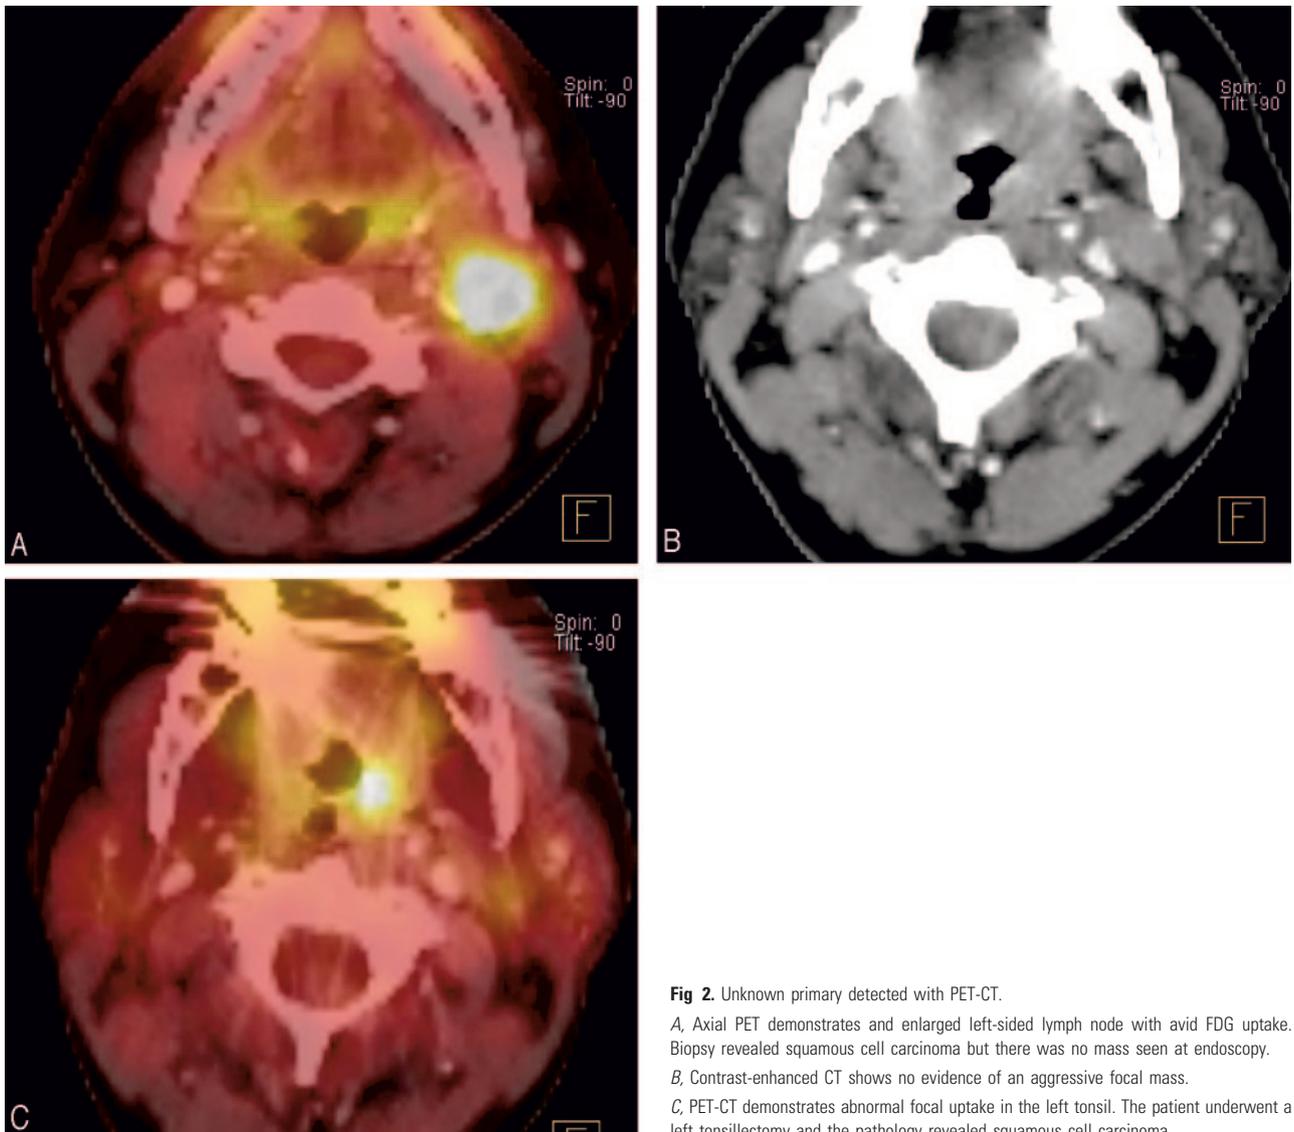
Unknown primary detected with PET-CT.
